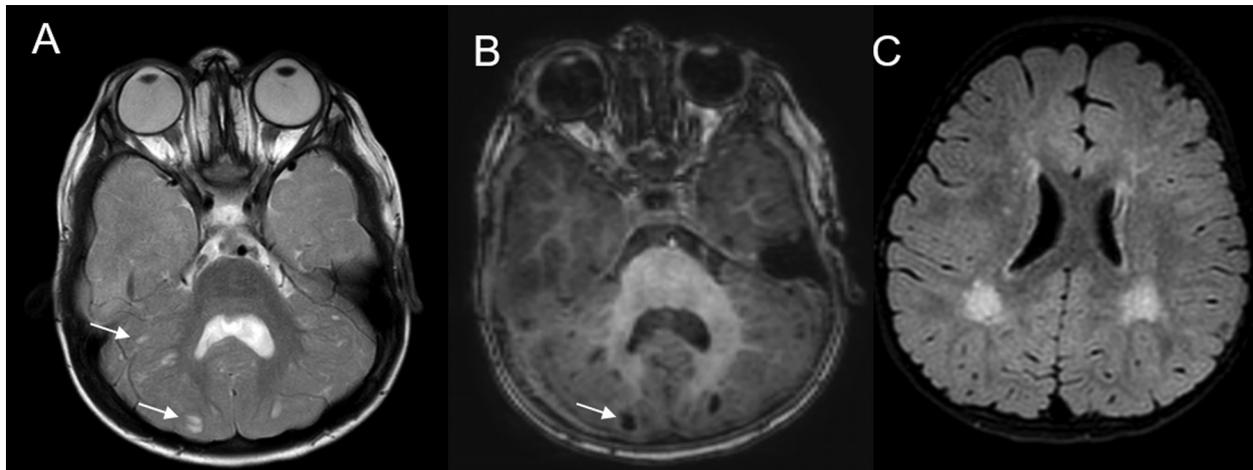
Axial magnetic resonance images (T2 (A), T1 (B), and fluid-attenuated inversion recovery (C)) of the posterior fossa showing cerebellar dysplasia with multiple cortical-subcortical cysts (white arrows). The fourth ventricle is dysmorphic, enlarged, and crescent shaped. In addition, bilateral peritrigonal periventricular white matter changes are also seen (FigC).
